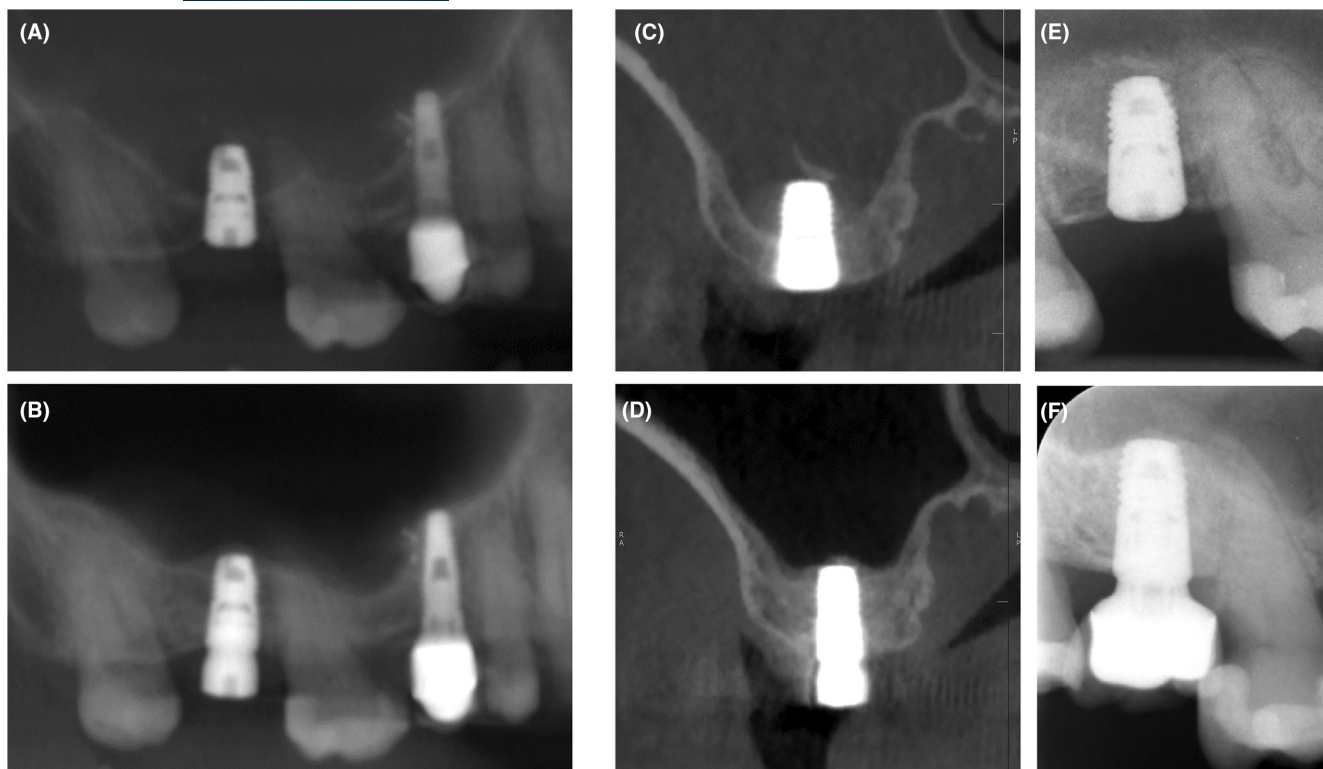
CBCT images (A, B): M-D; (C, D): B-P section, (A, C) immediately after transcresal sinus floor elevation using L-PRF as sole substitute; (B, D) after 4 months of healing Intra-oral long-cone radiographs; (E): at the day of surgery; (F): 4 years later.
